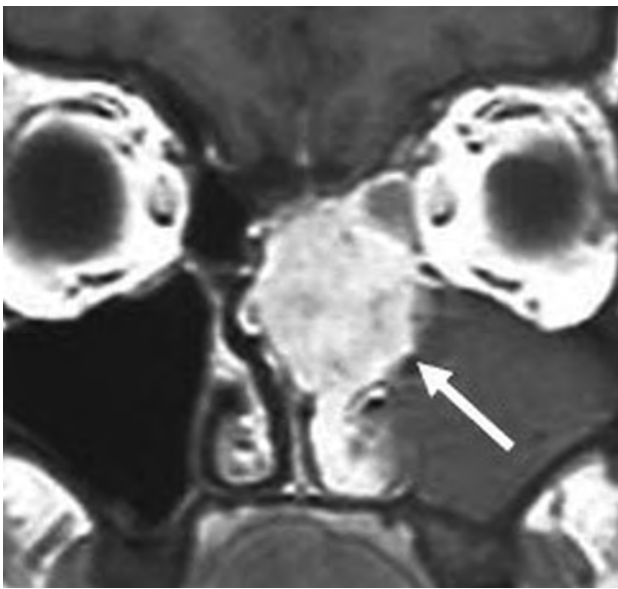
Renal cell-like adenocarcinoma. Coronal T1 postcontrast MR image shows an avidly enhancing, locally destructive, left nasoethmoid mass. The pronounced enhancement is akin to that of a renal cell carcinoma metastasis (*white arrow*). Images are courtesy of Dr Margie Brandwein, Mount Sinai Hospital.
